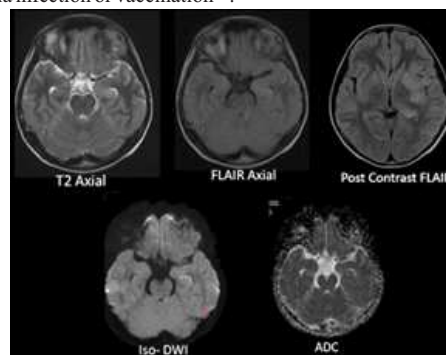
Case of an 18-year-old male patient with Post-Varicella Encephalitis, MRI shows multifocal FLAIR hyperintensities in the left lentiform nucleus, left insular cortex, bilateral thalami, left parietal gyrus, and left hippocampus, with subtle diffusion restriction. Additionally, subtle sulcal FLAIR hyperintensities are noted in the bilateral fronto-parietal regions.
